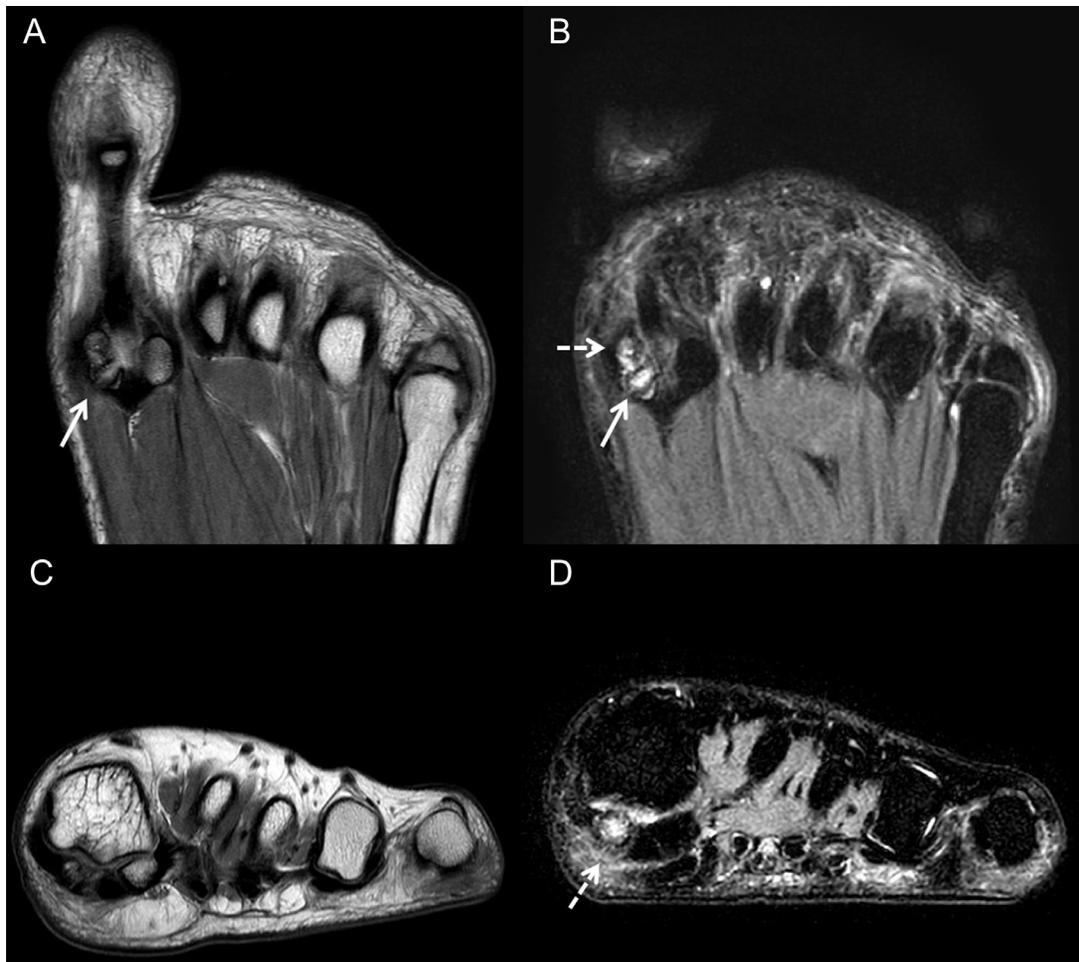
Selected coronal proton density (A), T2-weighted fat-suppressed (B), axial proton density (C), and T2-weighted fat-suppressed (D) magnetic resonance images showing a transverse fracture through the proximal fragment of the bipartite medial hallux sesamoid (solid white arrow) with marrow edema and distraction of the fracture fragments. Marrow edema is also noted in the distal fragment of the bipartite medial hallux sesamoid (dashed white arrow), possibly secondary to sesamoiditis.
